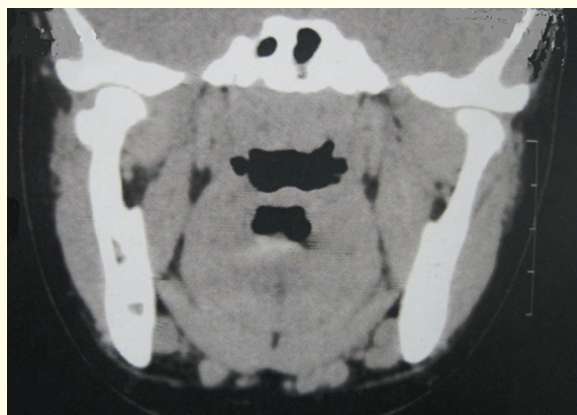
Computed tomography with 3D reconstruction showed no visible changes in relation to ankylosis.
